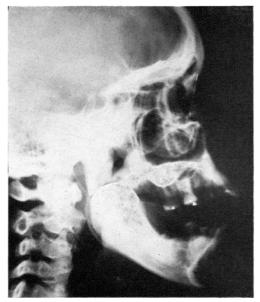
Post-operative X-rays showing position of the implant and mouth opening.
